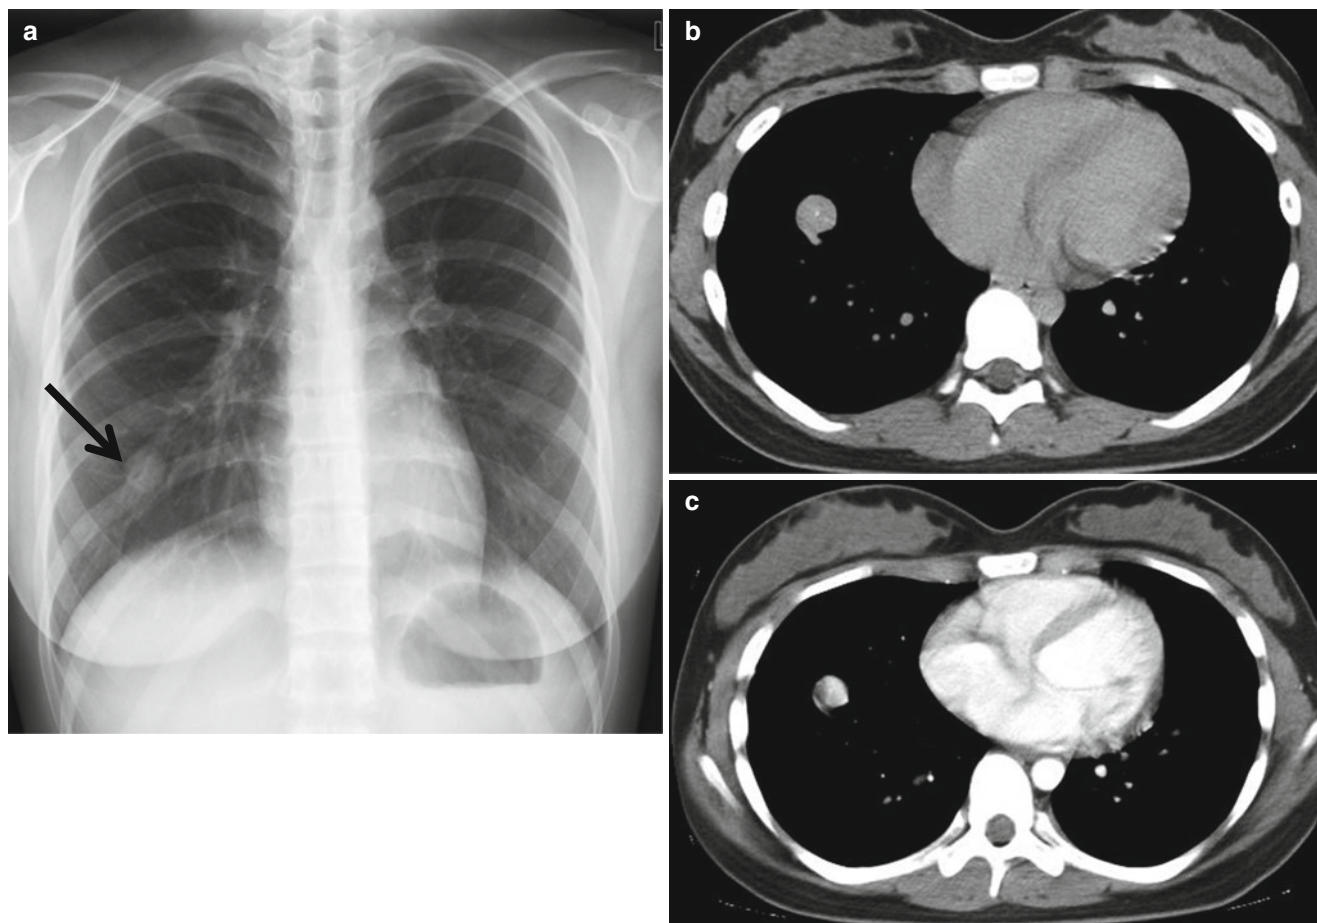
Intraparenchymal inflammatory myofibroblastic tumor in a 16-year-old girl. (a) Plain radiograph shows a rounded, well-circumscribed opacity in the right lower lung (*arrow*). (b, c)
